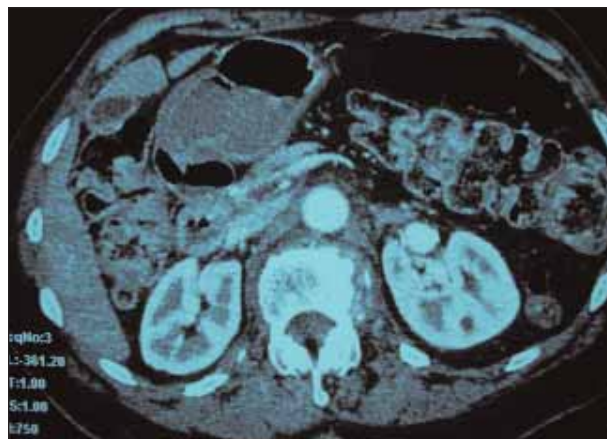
Contrast-enhanced CT scan depicting the left RAA.
